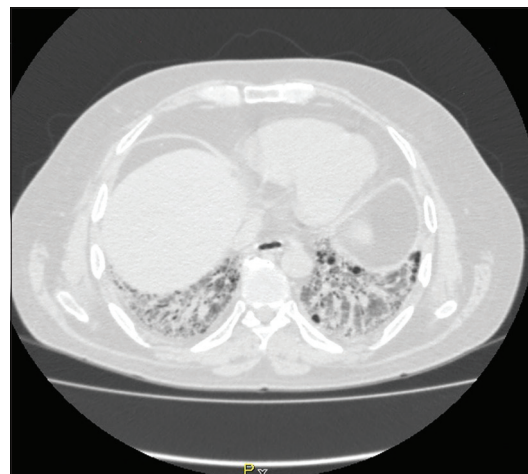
High-resolution computed tomography of the chest (lower lobe cuts) showing bilateral intralobular and interlobular septal thickening with subpleural honeycombing and diffuse ground glass haze during the episode of *Pneumocystis jiroveci* pneumonia
